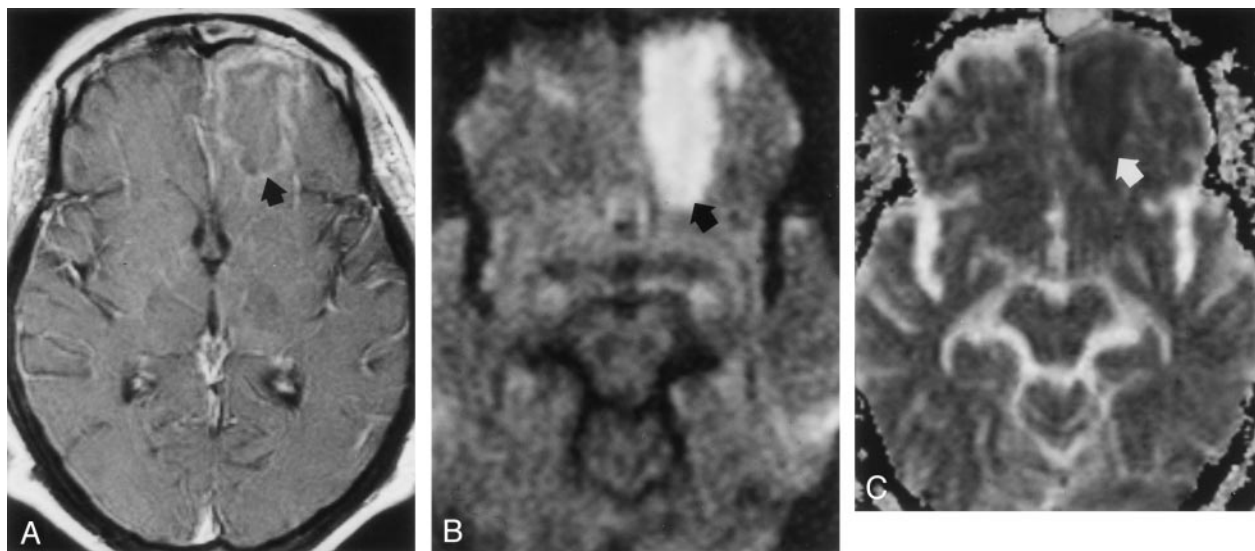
MR images acquired on hospital day 9 during the late stage of cerebritis or early stage of abscess. A, Contrast-enhanced T1-weighted image (650/17) shows thin, faint peripheral contrast enhancement around a left frontal mass (arrow). B, DW image ($b = 1,000 \text{ s/mm}^2$) demonstrates marked hyperintensity with a rim of even higher signal intensity (arrow). C, Restricted diffusion is indicated by hypointensity (arrow) on this ADC map. Mean ADC is $0.59 \pm 0.03 (10^{-3} \text{ mm}^2/\text{s})$.
